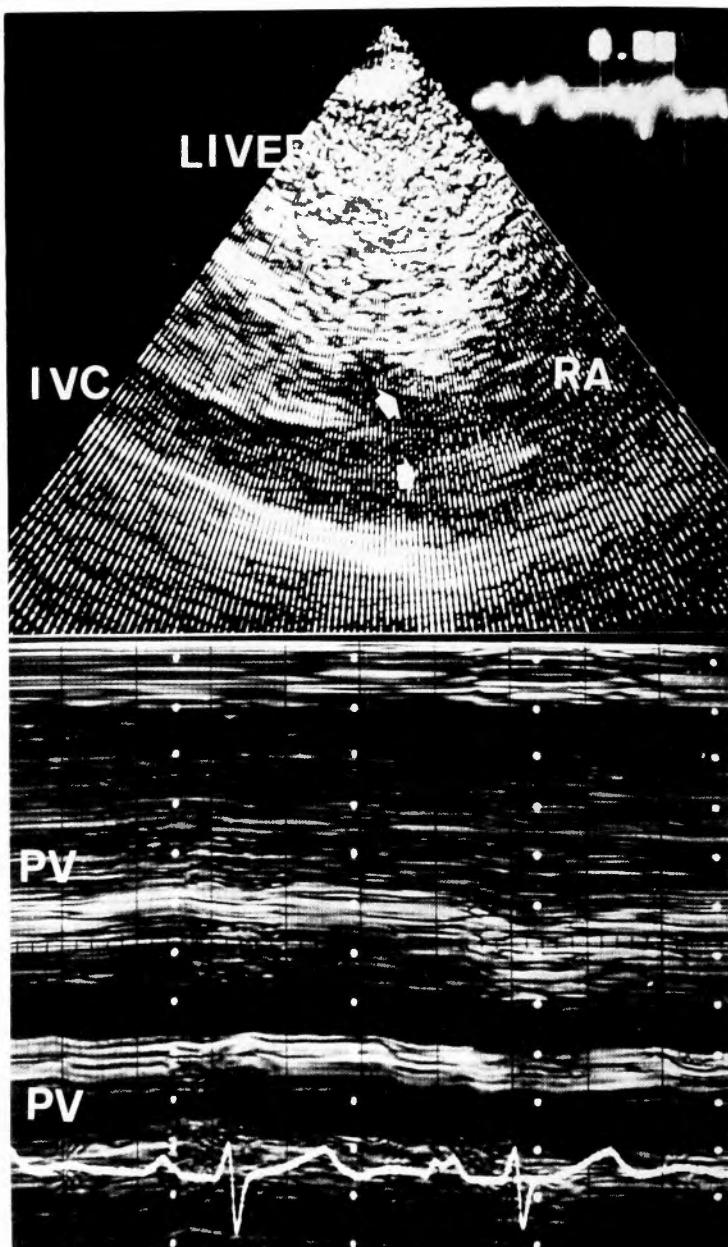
Echocardiography recorded nine years postoperatively (Patient 1)
